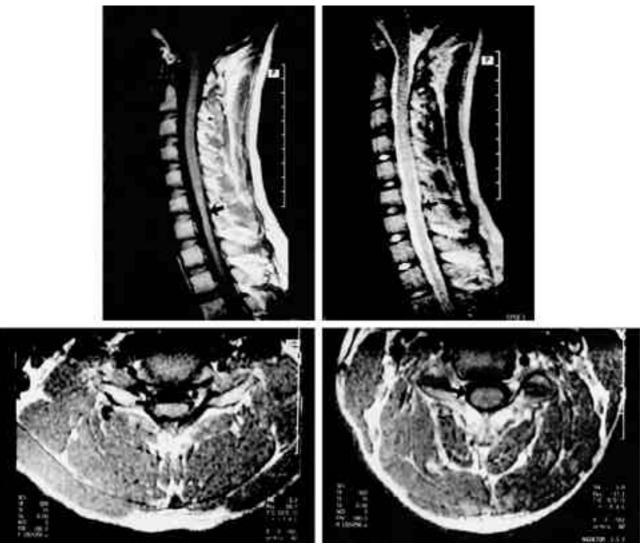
Cervical spine MRI findings in 16 year-old male (case 6). The sagittal T1, T2-weighted images (upper): showing the segmental cord atrophy (arrow) in the C6-C7 vertebral level. The axial T1-weighted images: showing the segmental cord atrophy in same region (left lower) compared to C2-C3 vertebral level (right lower).
